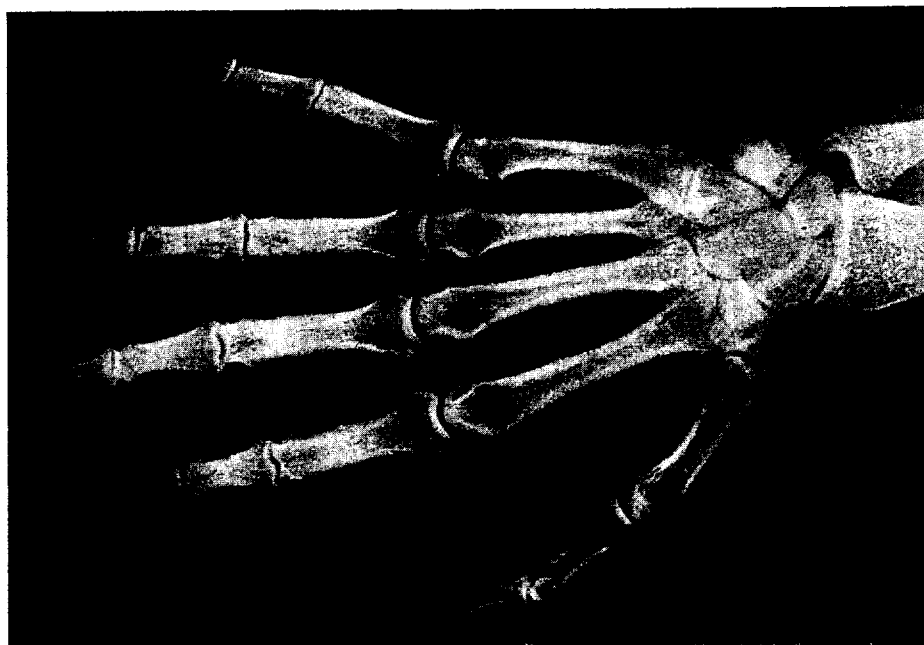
Radiography of the right hand of an average male of the same age as the injured worker presented for comparison with Fig. 19.
